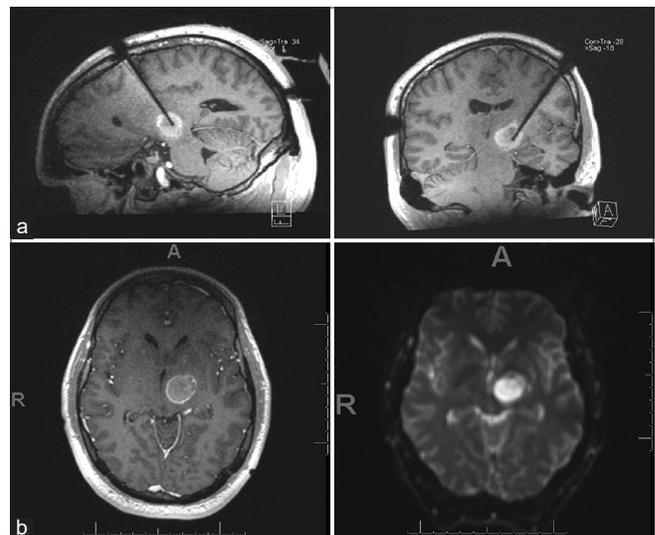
Intraoperative and immediate postoperative MRI. (a) Intraoperative MRI demonstrating laser probe position. (b) Immediate postoperative T1-weighted post-contrast and diffusion-weighted images.
